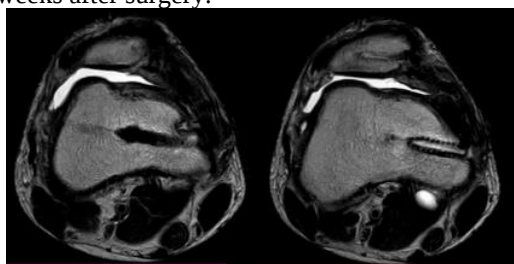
MRI of the right knee after revision of the MPFL reconstruction.
